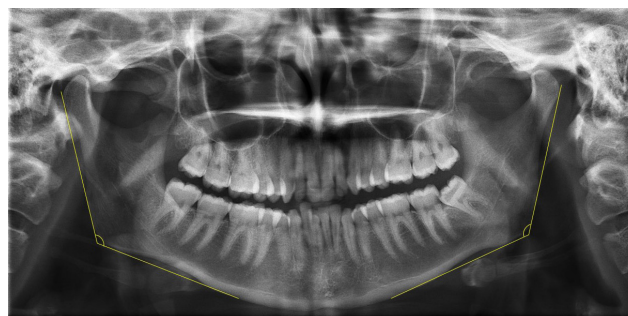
Gonial angle measurement on the digital panoramic radiograph
